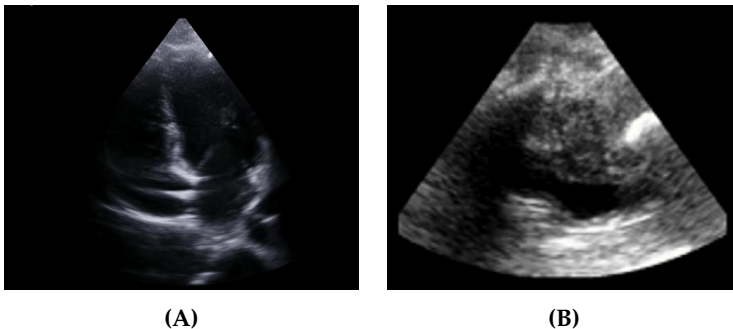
Examples of US images. (A) Apical four chamber view of the heart. (B) Transperineal US image of the male pelvic region.
